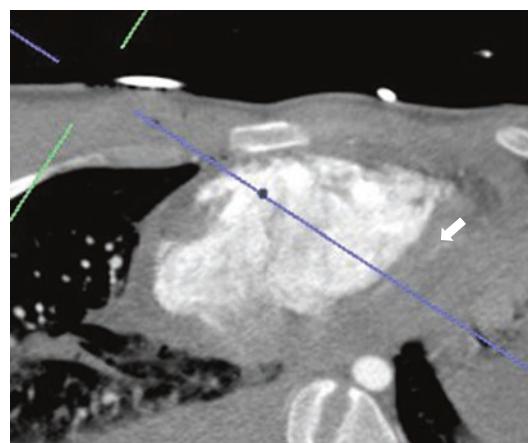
Twenty one-year-old man presenting with precordial stab wound. Oblique trajectography CT image shows wound extension to the right ventricle (line) with small hemopericardium (arrow). Figure adapted with the author's permission from Dreizin D, Munera F. Multidetector CT for penetrating torso trauma: state of the art. Radiology. 2015;338:55.
